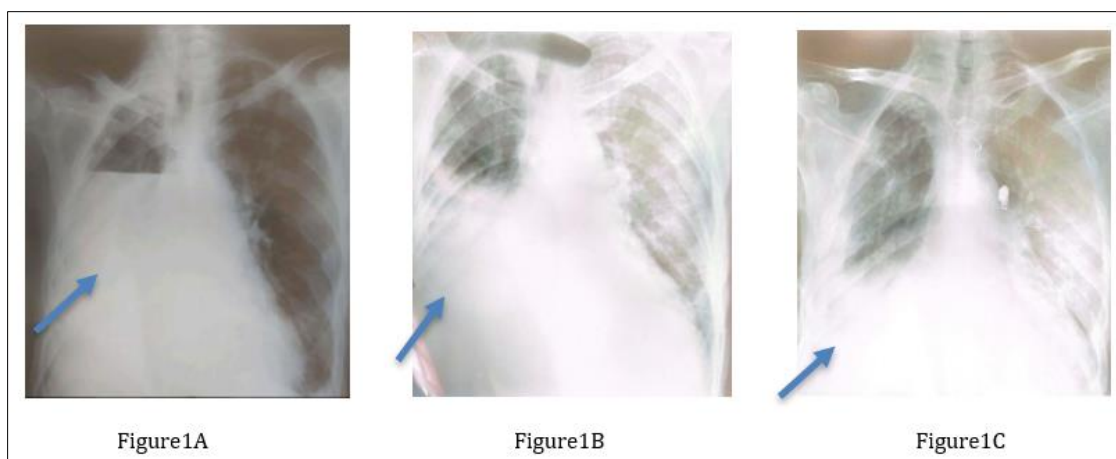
Chest X-rays taken during hospitalization show significant evolution following the drainage of the pulmonary abscess. Before drainage, the imaging revealed a round opacity with a characteristic hydro-aerial level indicative of a purulent collection in the right lower lung. After chest drainage, the post-intervention X-rays (figure: 1B, 1C) showed early signs of radiological clearance, indicating a reduction in opacity and improvement in pulmonary aeration
